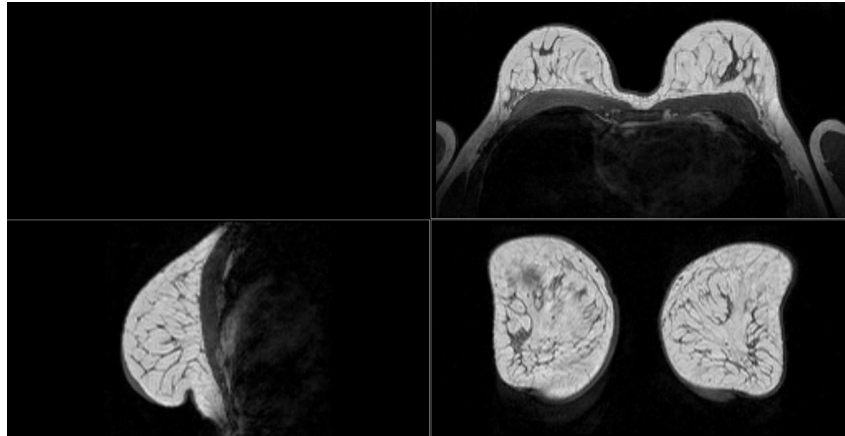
Example of T1 non-fat suppressed MRI image
